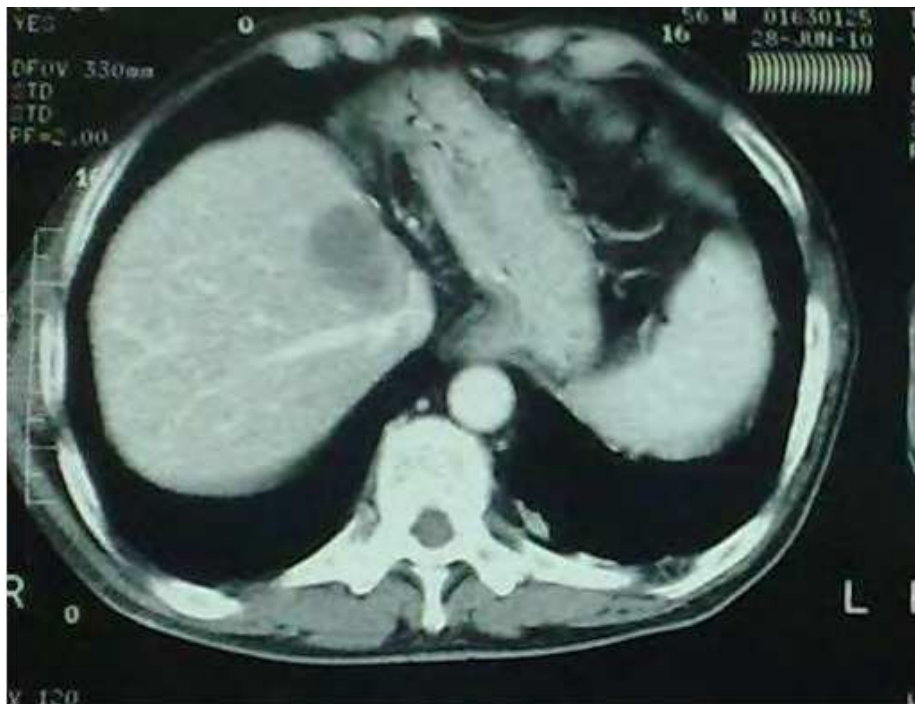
a, b: (a) CT of a CRC hepatic metastatic lesion in a patient that had undergone a previous left hepatectomy for another metastatic lesion. (b) Nonanatomical repeat resection of metastatic lesion in close proximity to the hepatic veins.
